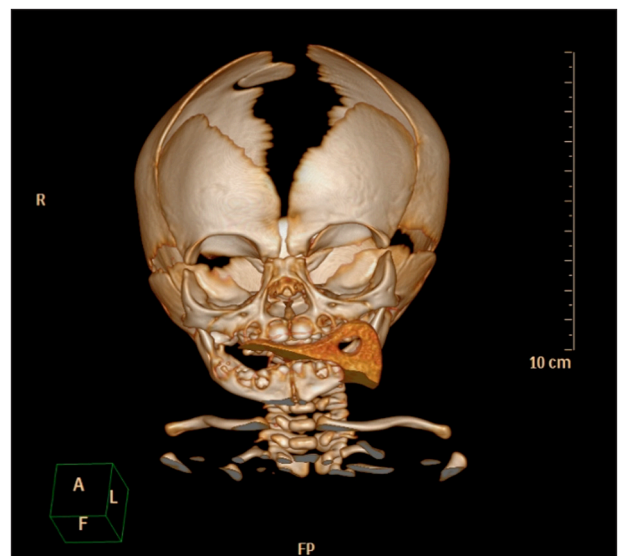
Frontal view of 3D cranio-encephalic CT scan highlighting large anterior fontanelle.
